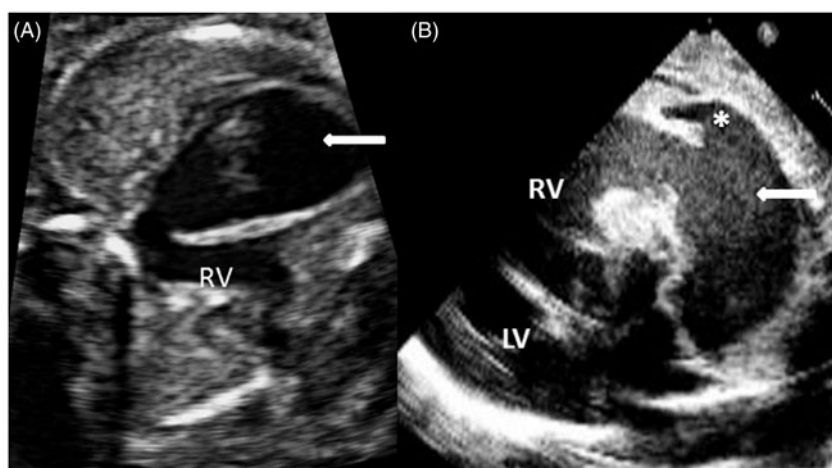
Aneurysm of right ventricle: foetal and neonatal echocardiography. Huge aneurysm of free right ventricular wall (arrow) during antenatal screening in patient no 7. B. Postnatal long-axis view with markedly dilated right ventricle (RV) and pseudoaneurysm (arrow). Left ventricle (LV) small in comparison.
